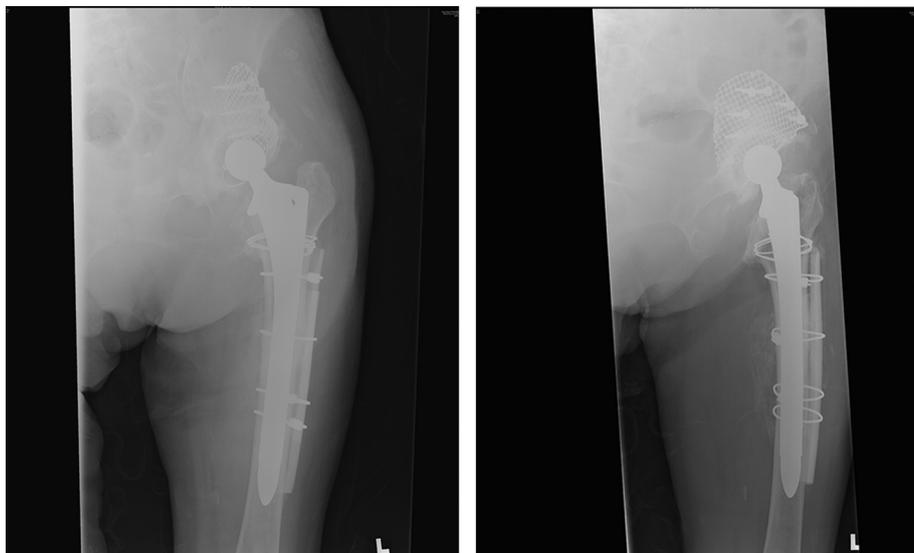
Postoperative anterior–posterior and lateral radiograph showing total hip replacement with cemented acetabular component and impaction bone graft for acetabular bone defect. The subtrochanteric fracture was reduced and an extensively porous coated press fit long femoral stem was used.
